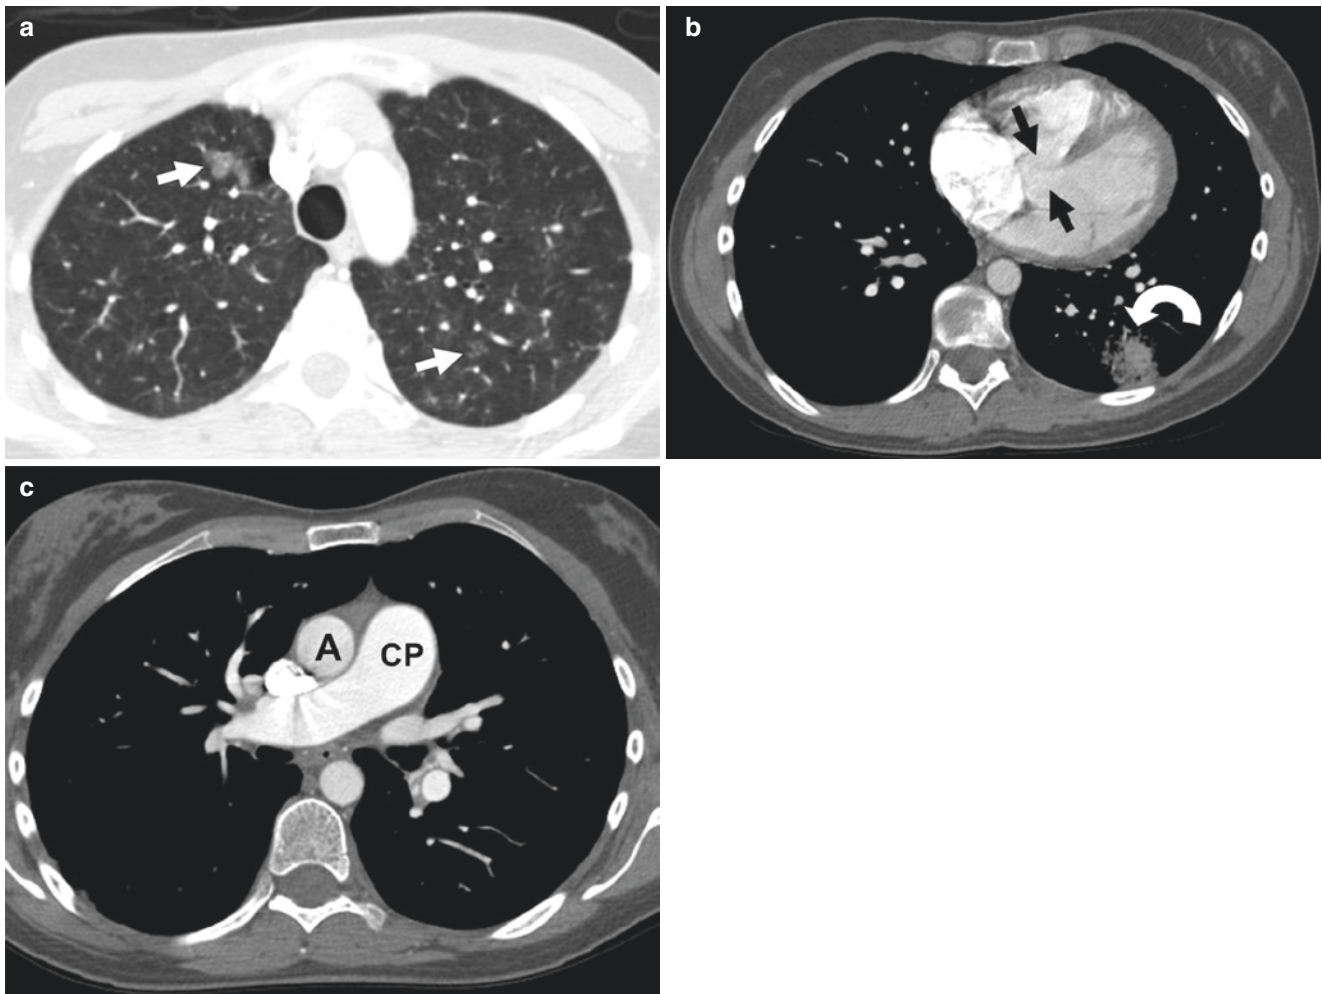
Twenty-nine-year-old girl with Eisenmenger syndrome physiology who presented with pulmonary hypertension. (a) Axial lung window CT image shows areas of somewhat nodular and lobular ground-glass opacities (*arrows*). (b) Contrast-enhanced axial CT image
